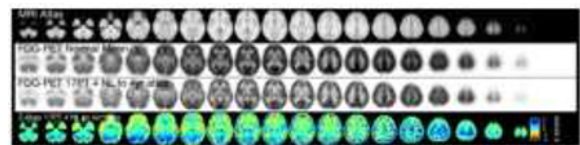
FDG PET data for a 4 year-old epilepsy patient in 4 year atlas space. Compared to mean normalized FDG PET data, z-scores indicate hypometabolism in the right temporal and left frontal regions. The radiologist's report noted hypometabolism in the right lateral temporal lobe and left frontal cortex.
